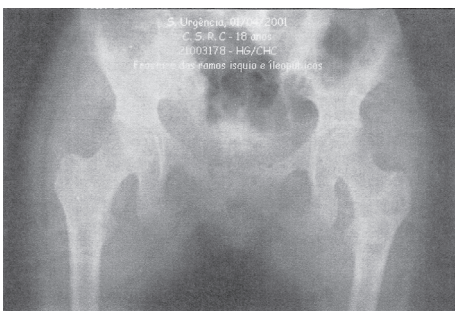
X-ray of the fractured pelvis
